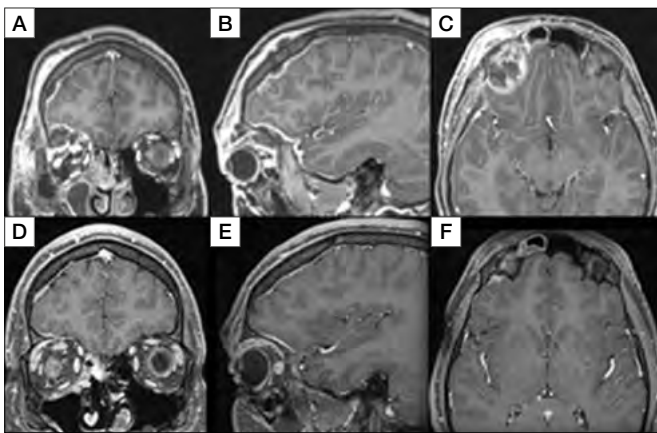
MRI-based evaluation of a right orbital and epidural abscess. In A, B and C the pre-operative findings. In D, E and F the post-operative imaging after a superior eyelid approach to orbit and anterior cranial base.
